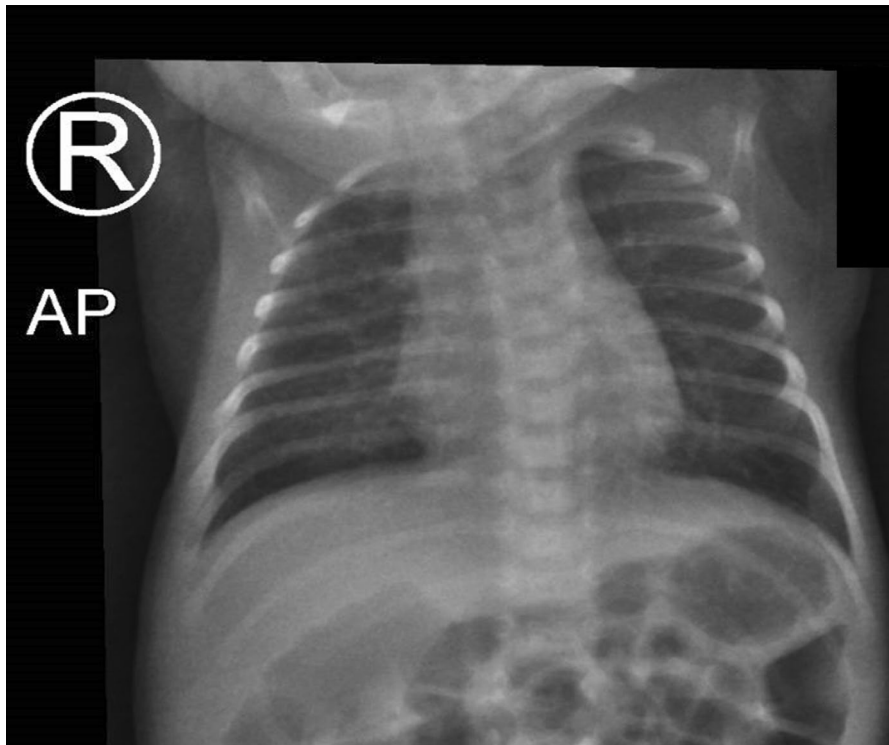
Admission chest X-ray for the case.
